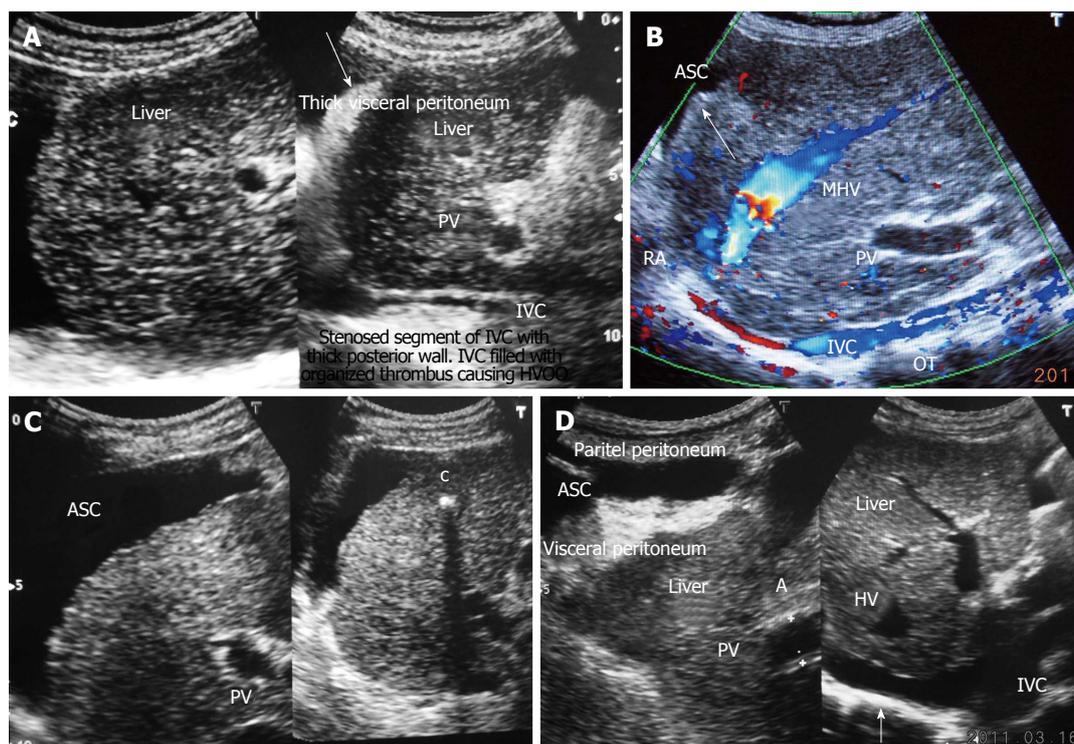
Ultrasonography showing ascites and evidence of chronic peritonitis in a patient with cirrhosis. A: Acute exacerbation in a patient with liver cirrhosis showing hepatic portion of the inferior vena cava (IVC) filled with organizing thrombus and ascites with thick visceral peritoneum-indicating presence of bacterial peritonitis; B: Ultrasonography of a patient with liver cirrhosis due to HVCS: showing long segment stenosis of IVC with thick old organized thrombus (OT) along the posterior wall of the hepatic portion of the IVC. Note the presence of ascites (ASC) and irregular margin of the liver indicated by an arrow. Middle hepatic vein (MHV) is obstructed at its orifice and shows distal segmental stenosis; C: Ultrasonography of a patient with liver cirrhosis due to HVCS showing inferior vena cava stenosis, a calcified focus (c) in the liver and ascites; D: Ultrasonography of patient with liver cirrhosis due to HVCS showing IVC stenosis with organized thrombus on posterior wall and ASC and thick visceral peritoneum, suggestive of chronic bacterial peritonitis. PV: Portal vein; HVCS: Hepatic vena cava syndrome; RA: Right atrium; HV: Hepatic vein.
